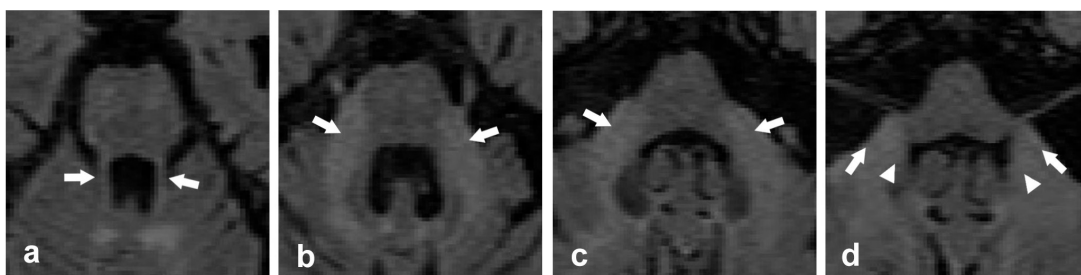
Neuroimaging axial T2 FLAIR findings in a 73-year-old male with FXTAS (stage 5) who exhibits intentional and resting tremors, parkinsonism, cerebellar ataxia, and deficits in attention, concentration, and working memory. Axial T2 FLAIR images show (a) the SCPs (arrows), (b) hyperintense signal at the MCPs (arrows), commonly known as the MCP sign, and (c,d) hyperintensities at both the MCPs (arrows) and ICPs (head arrows).
